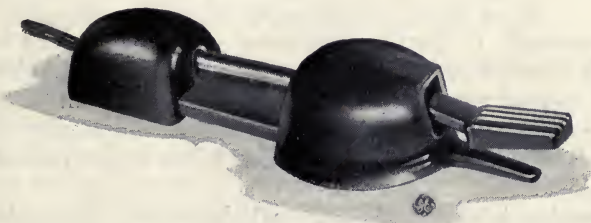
Foot switch for electrosurgical apparatus. (Courtesy of the General Electric X-ray Corporation.)
